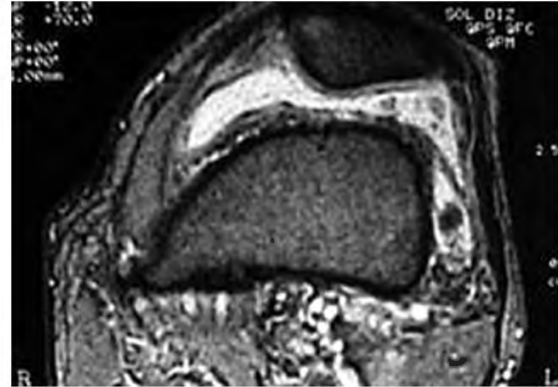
Axial, T2- weighted GRE MRI of the same patient
